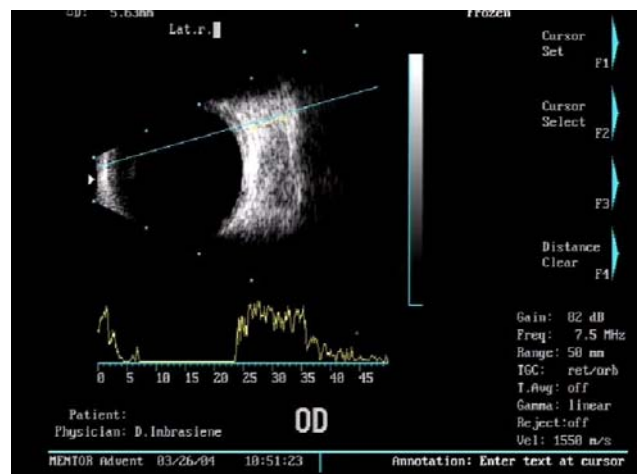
In ultrasonographic B-scan of the lateral part of the orbit, thickened lateral muscle is seen (its width 5.63 mm)
